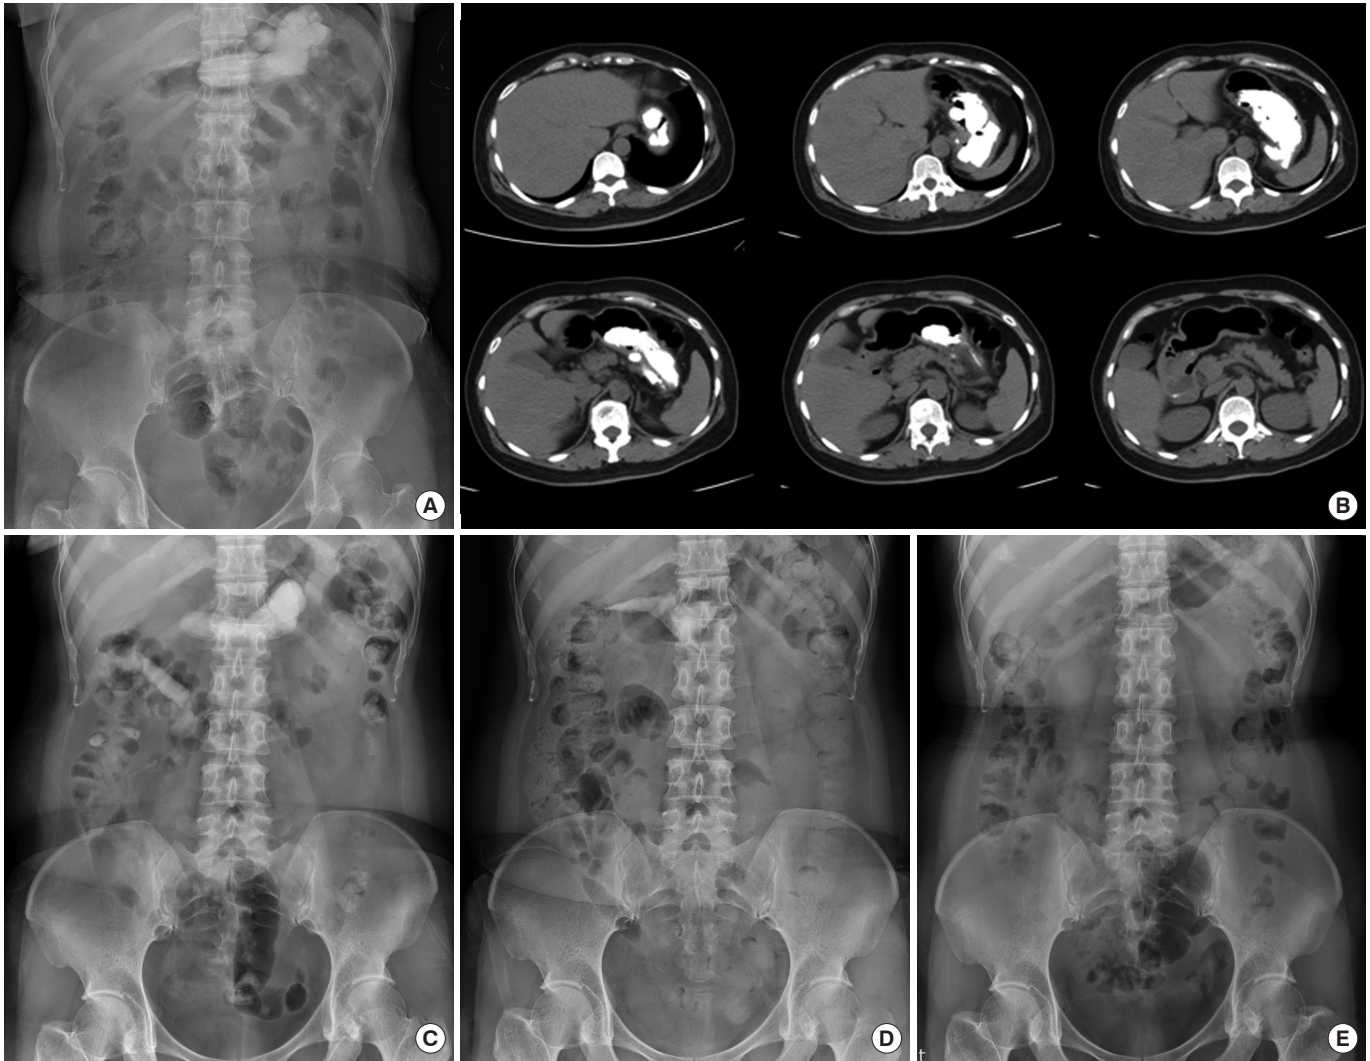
Gastric cast on plain abdominal radiographs and abdominal computed tomography scan of (A, B) at the emergency department, (C) hospital day 4, (D) hospital day 7, and (E) 3 weeks after discharge.
